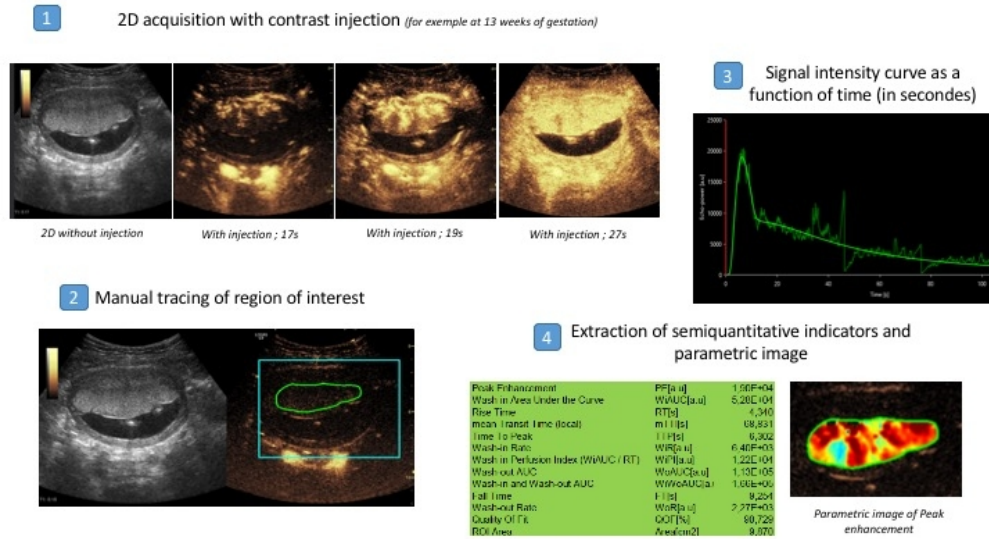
Contrast-enhanced Ultrasound (CEUS) Analysis
